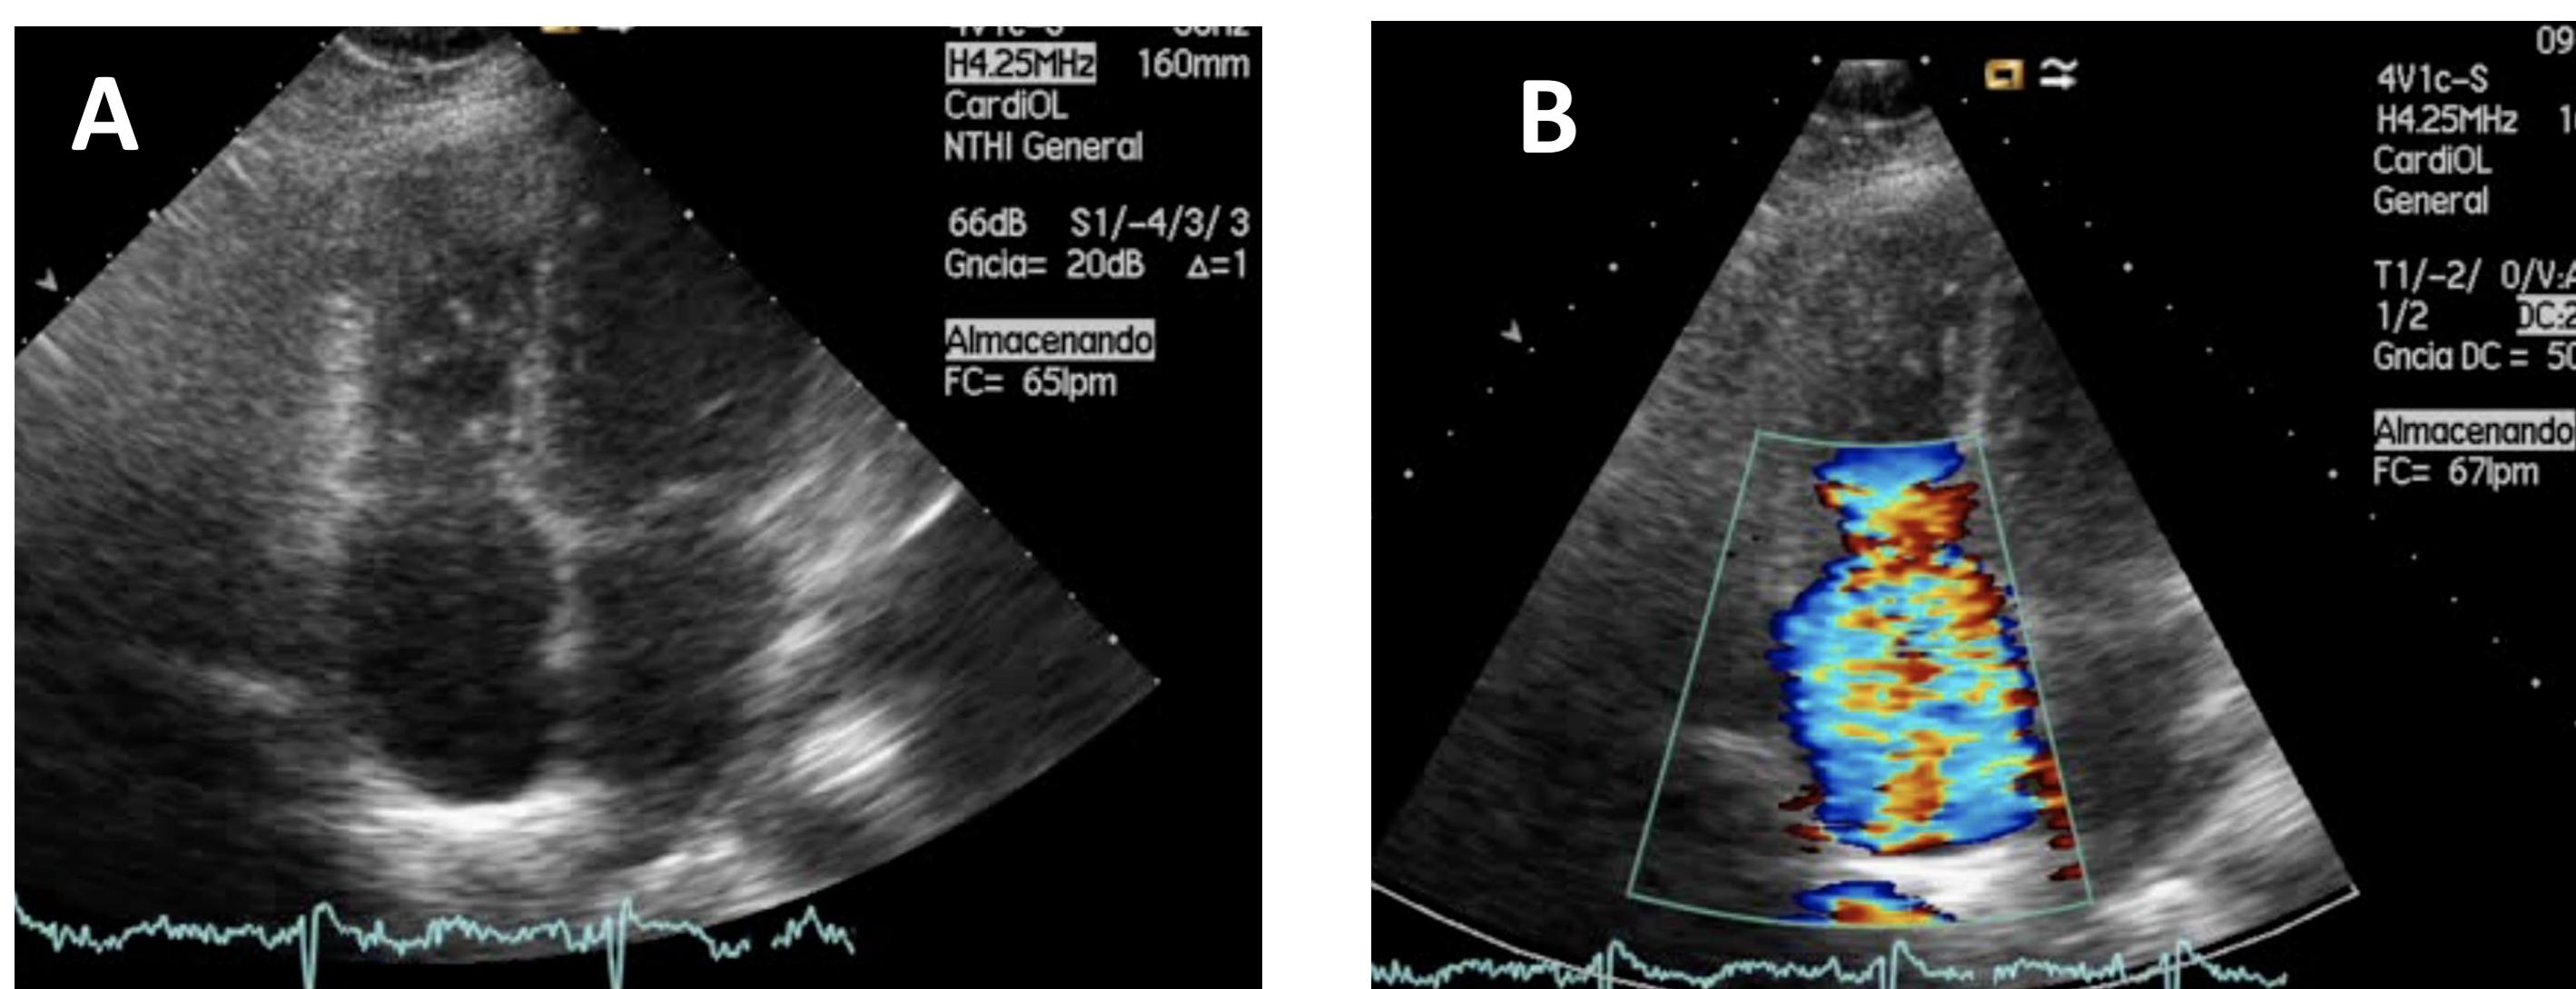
A: Echocardiogram apical 2-chambers view ( RV-focused,) showed tricuspid affection. Image B: Free severe regurgitation in Doppler color flow.
